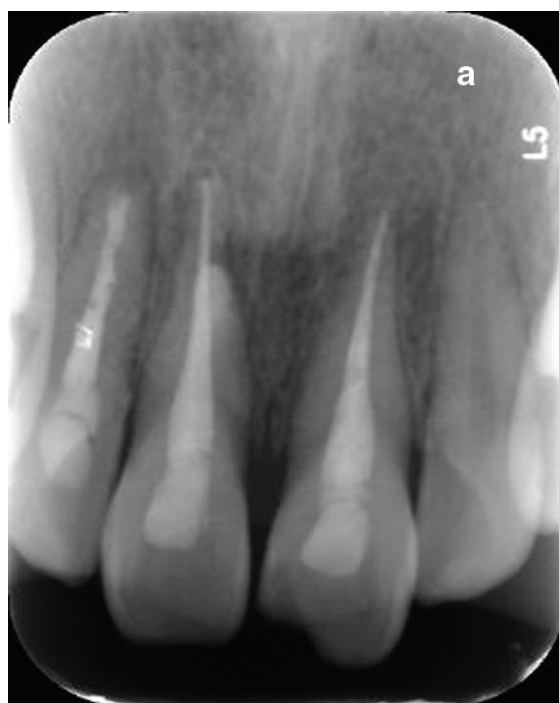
(a) A 6-month follow-up radiograph showed the healed lesions of teeth 11 and 12; there were no signs of root resorption of the affected teeth 11 and 12; (b) a 12-month follow-up radiograph showed no sign of root resorption of the affected teeth 11 and 12.
